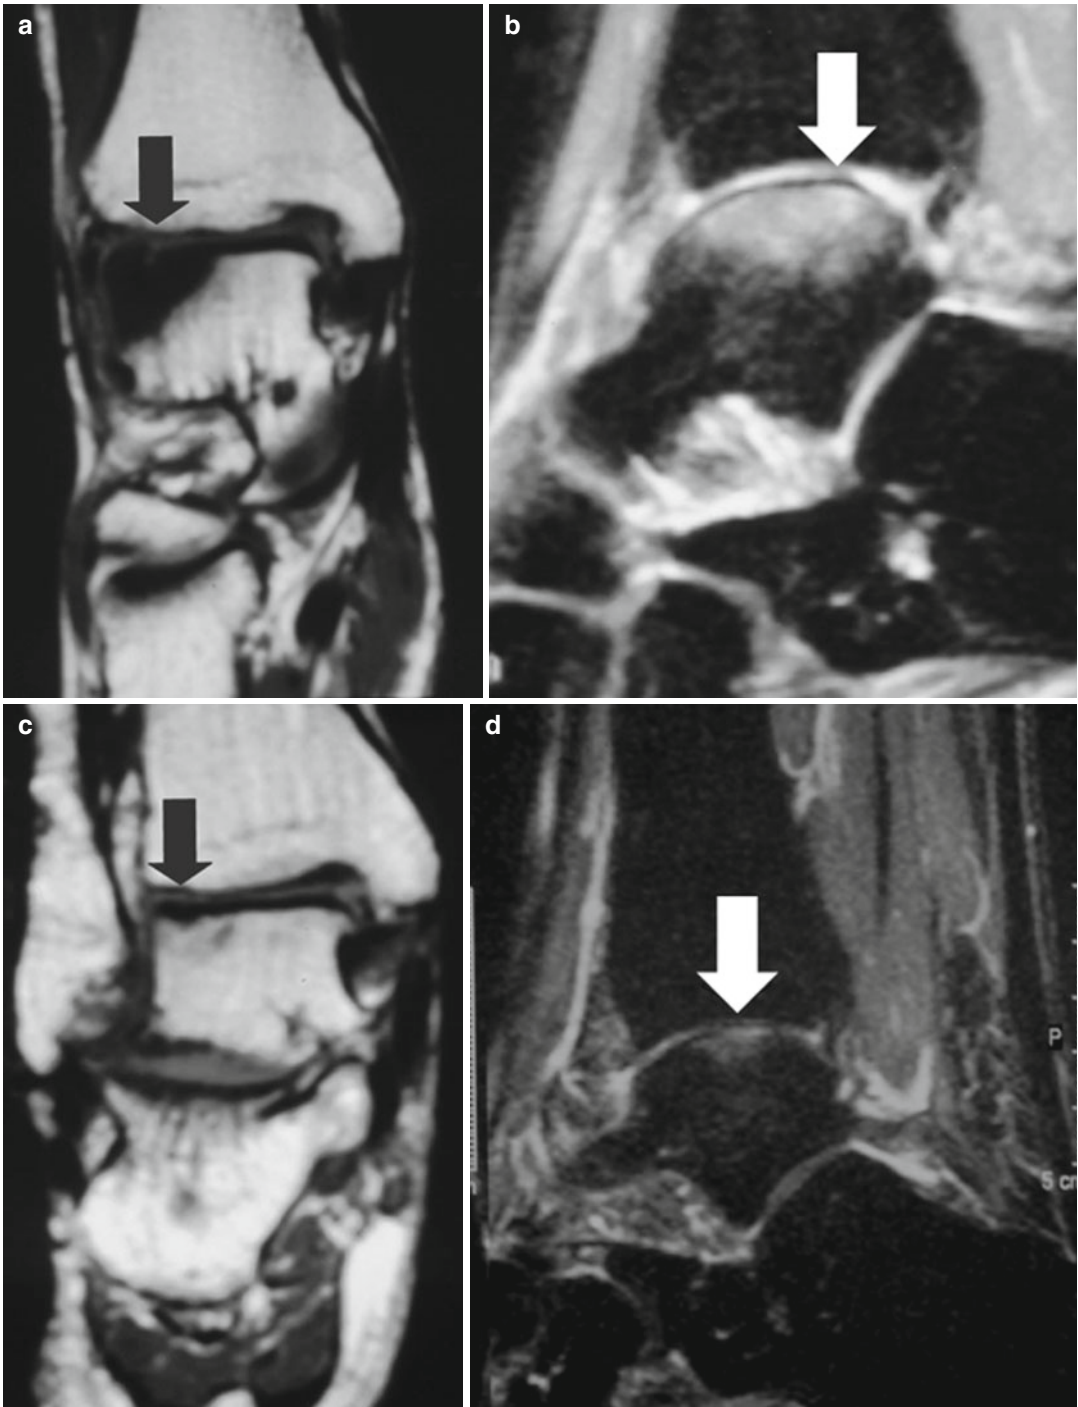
Preoperative T1-weighted (a) and STIR (b) MRI images of a large osteochondral lesion (*arrow*) of the lateral aspect of the talus treated with BMAC and scaffold. Two-year post-operative T1-weighted (c) and STIR
